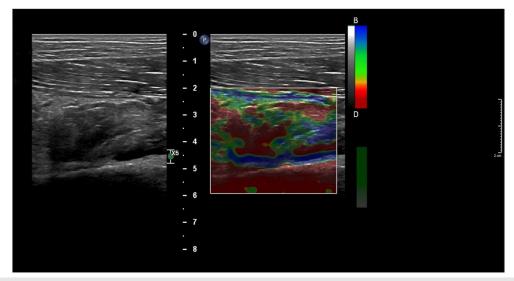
Stream ultrasound image at the end of the physiotherapy treatment.
